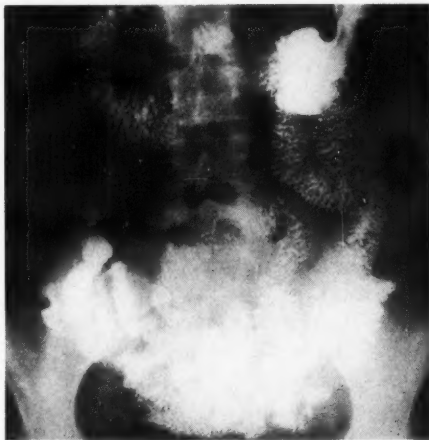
The normal small intestine on the roentgenogram.
